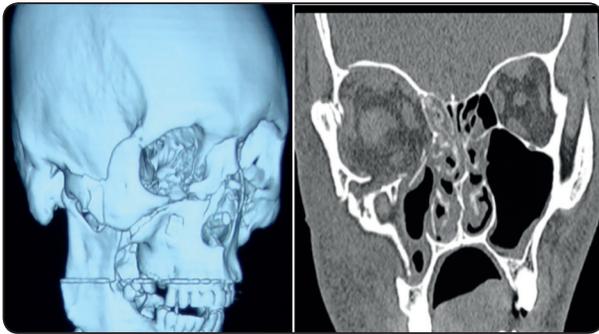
CT images showing mid-face fractures associated with orbital fracture.
